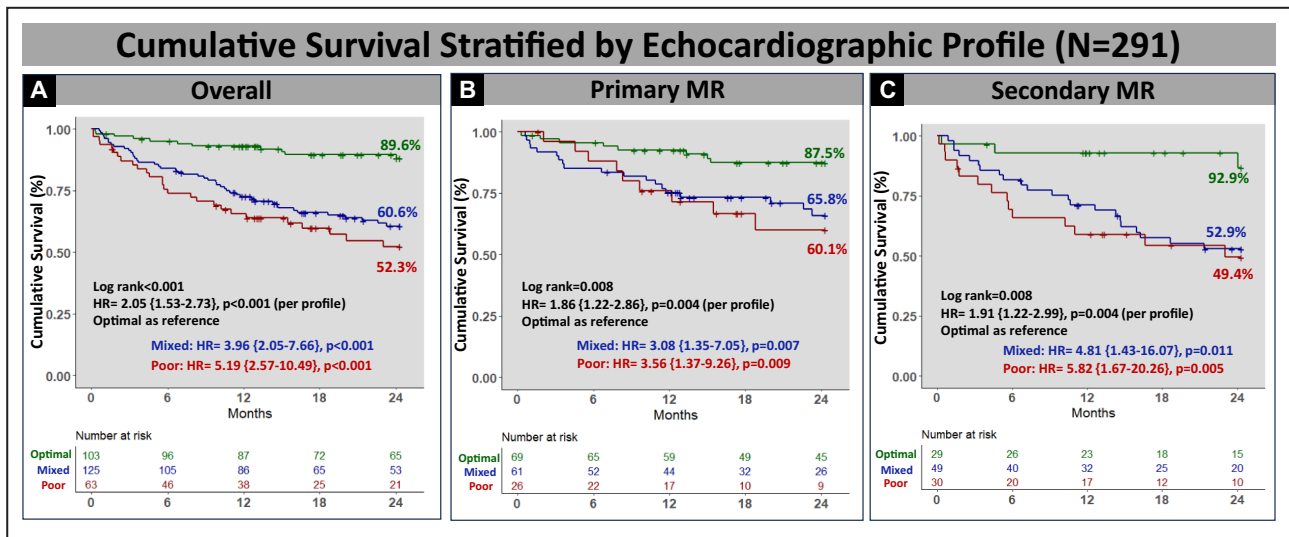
Cumulative survival based on echocardiographic profile. Compared with patients with poor profile, optimal profile had superior overall (A) survival and in patients with primary (B) and secondary (C) MR. HR indicates hazard ratio; MR, mitral regurgitation; TMPG, transmitral mean pressure gradient; and TR, tricuspid regurgitation.
